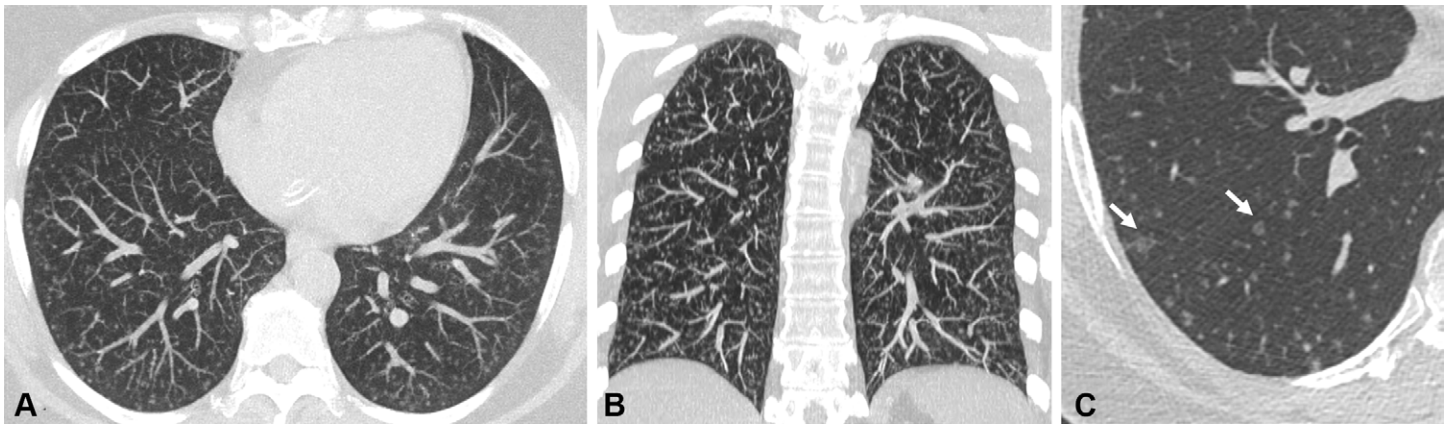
DPM in a 52-year-old woman with chronic exertional dyspnea. The patient had no history of smoking, illicit drug use, occupational exposure, or pets. Axial (A) and coronal (B) maximum intensity projection CT images demonstrate numerous small nodules throughout both lungs in a random distribution. Close-up axial CT image (C) shows that some nodules (arrows) have central clearing (Cheerio sign).
